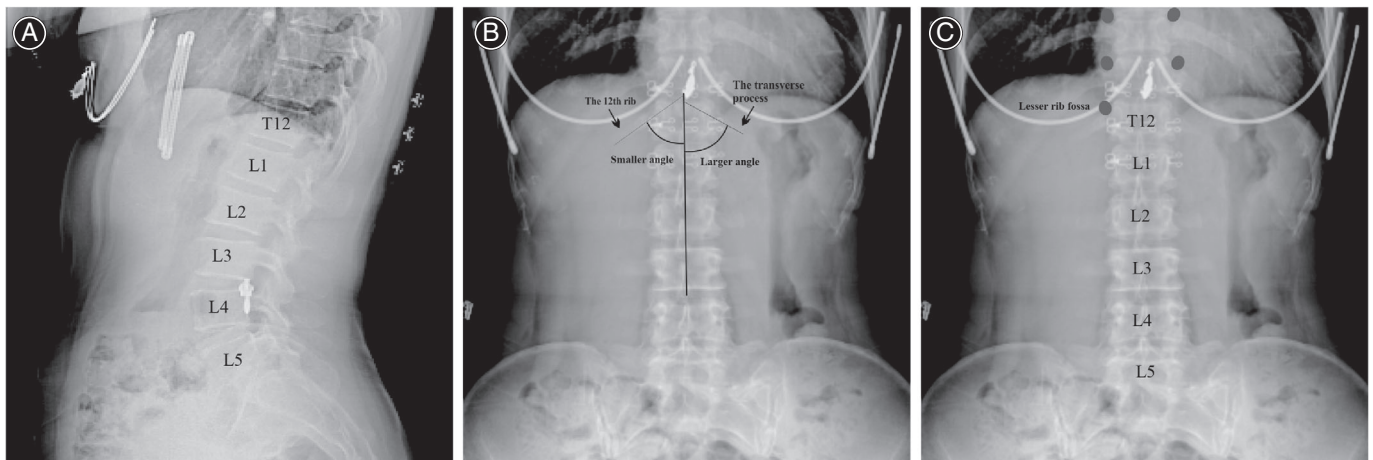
An example of a unilateral 12th rib to distinguish the poorly developed 12th rib from the first lumbar transverse process. (A) The poorly developed rib could not be viewed in the lateral X-ray image. (B) A smaller example of a unilateral 12th rib to distinguish the poorly developed 12th rib from the first lumbar rib vertebrae angle (RVA) between the rib and the anterior midline of vertebral body in the posteroanterior view. (C) There was a “lesser rib fossa” at the junction of ribs and vertebrae in the posteroanterior view.
